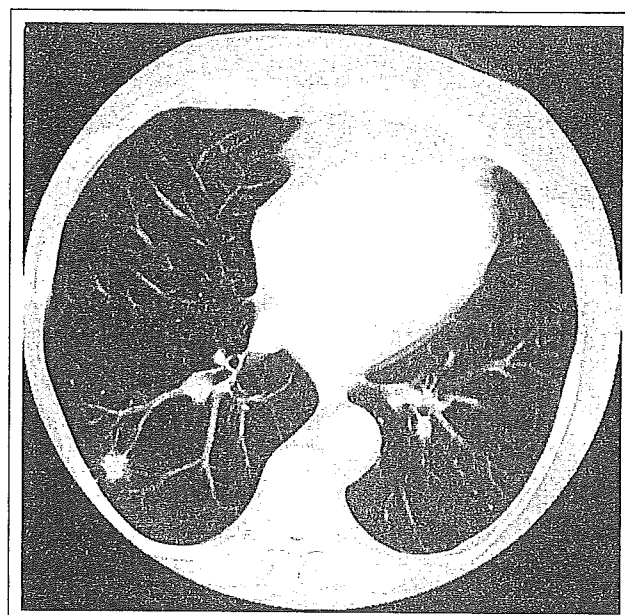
Solid nodule. Chest computed tomography image at the level of right inferior pulmonary vein shows a 1-cm solid nodule with feeding vessels.
